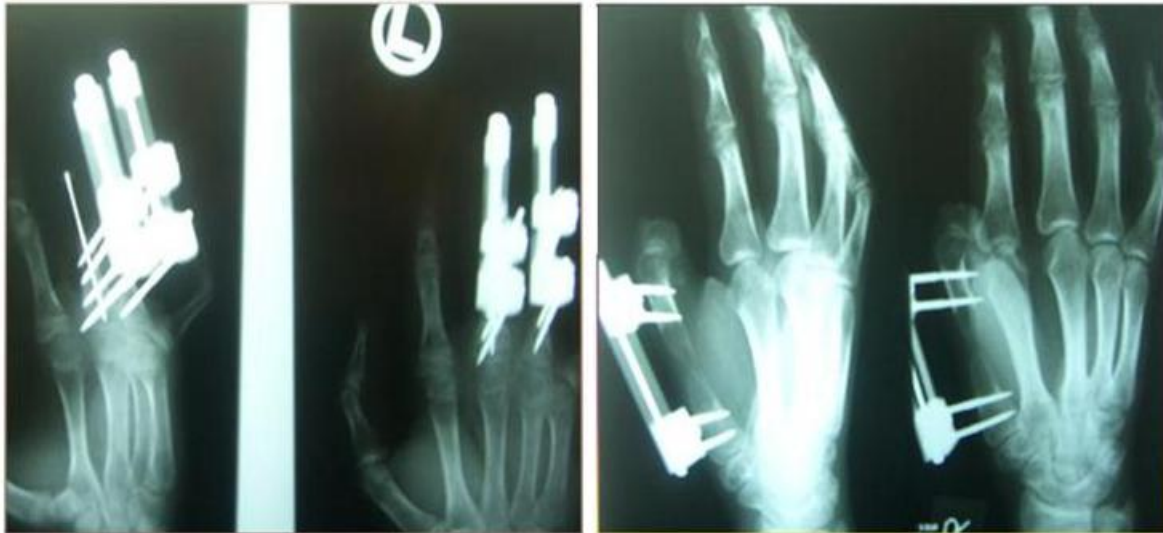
X-ray images of osteodistraction with and without K-wire
